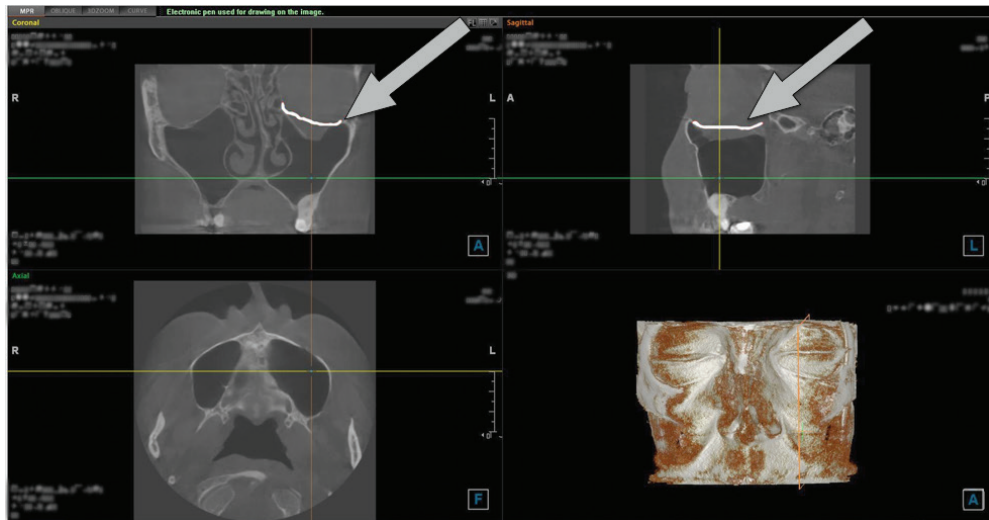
Fracture of the bottom wall of the orbit – visible on standard CT images viewer
